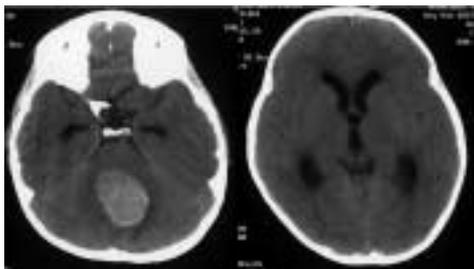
CT scanning revealing a hemorrhagic lesion in the 4th ventricle.
